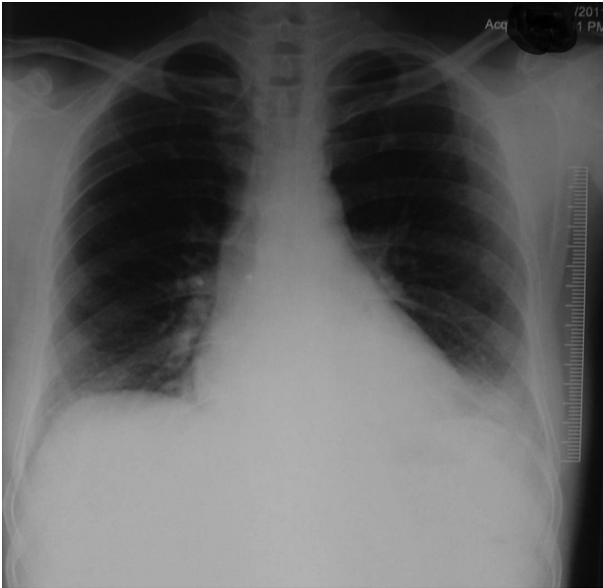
Chest X-ray PA showing left perihilar and lower zone opacity.
